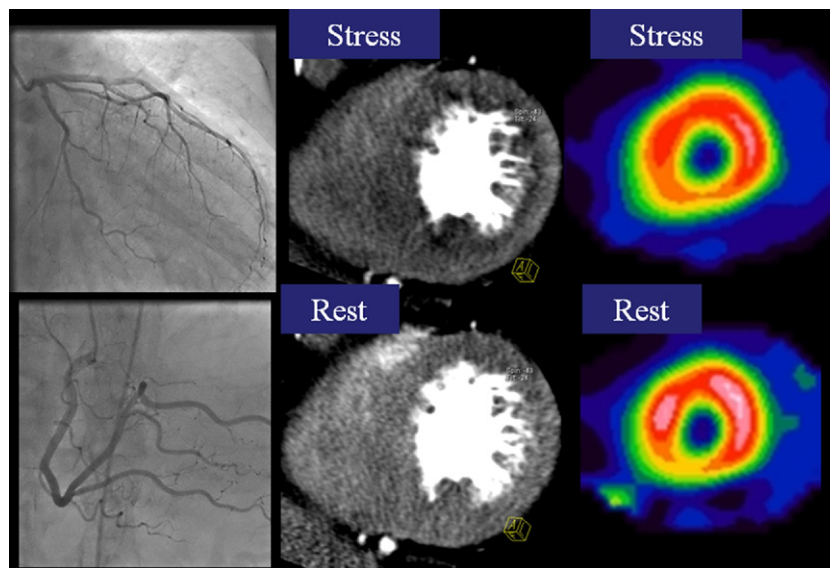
Example of False-Positive CT Perfusion
